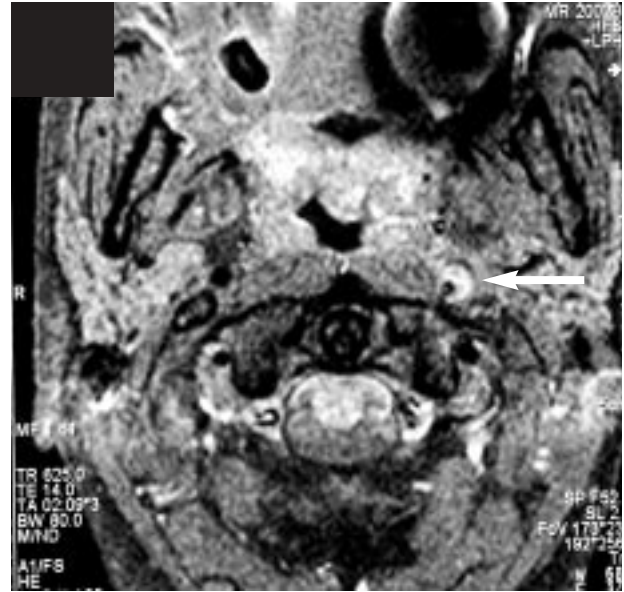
MRI cross section showing left-carotid dissection (arrow).
